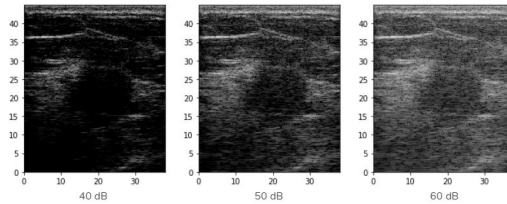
B-mode Ultrasound for Varying dB Thresholds
